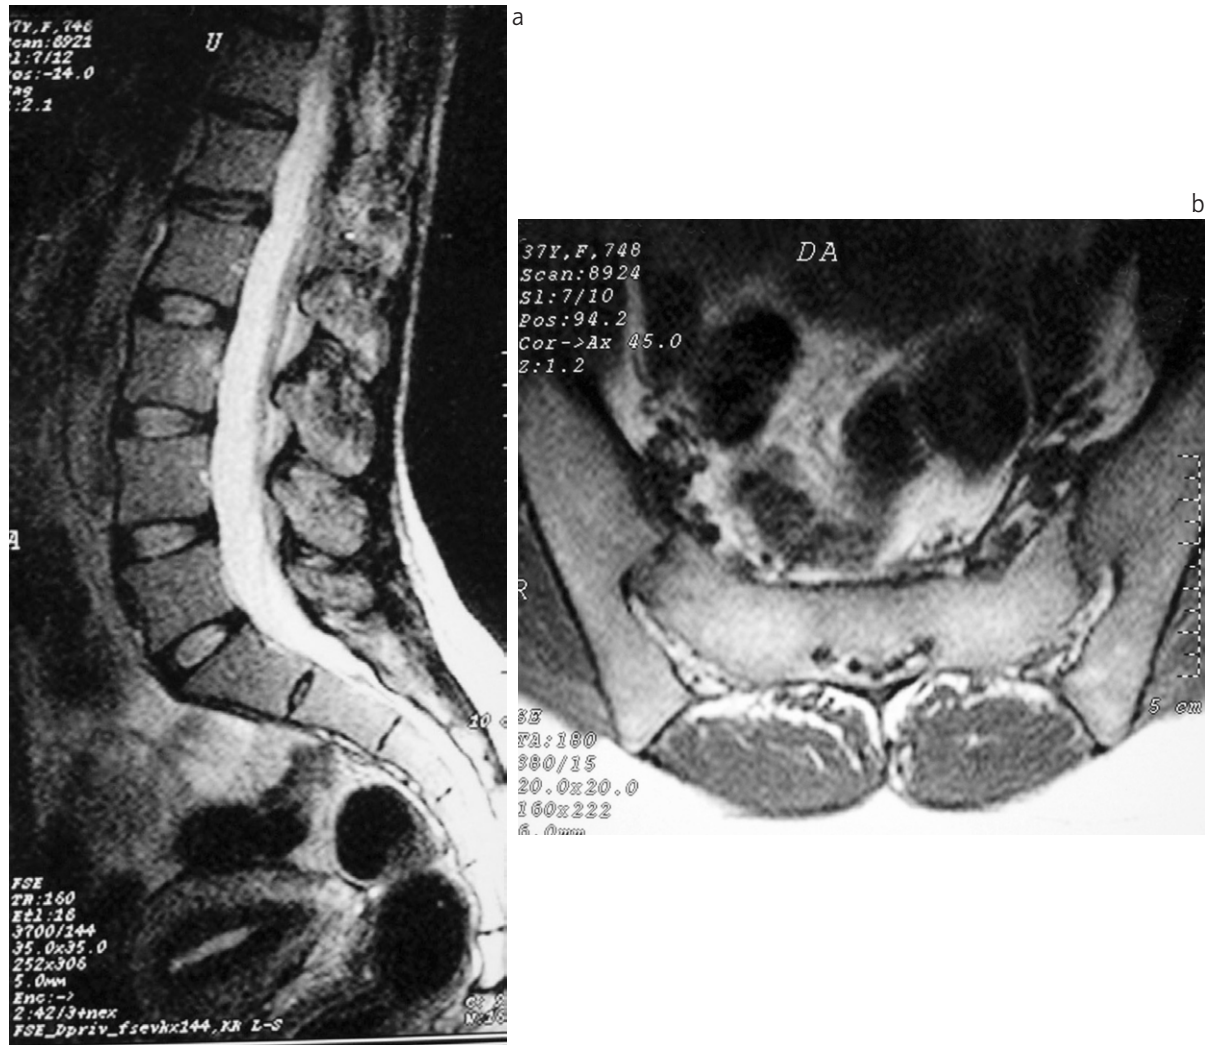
Control MRI in sagittal projection (a) and axial projection (b) presents the condition following complete excision of the tumour
